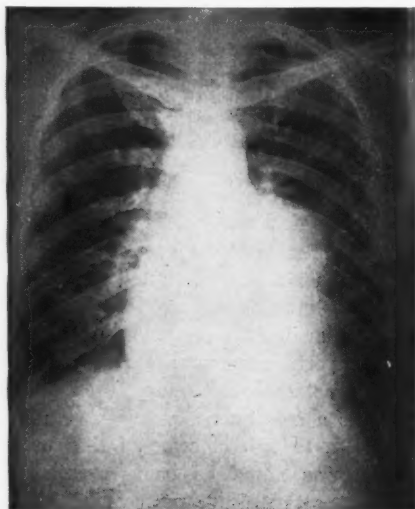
X-ray film of the patient's chest.
